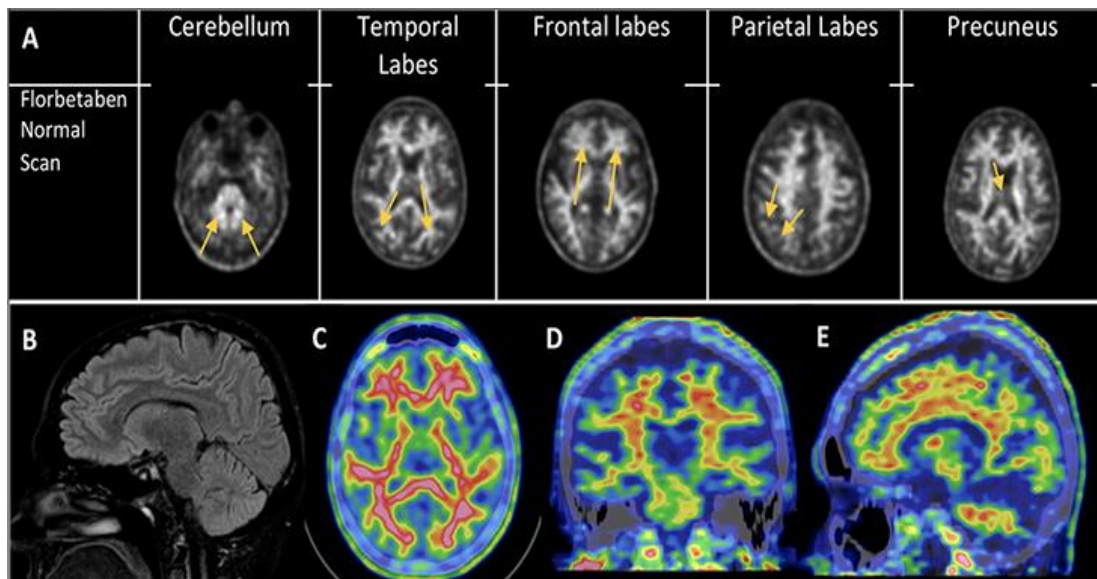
Woman, 52 years old, with neurodegenerative diseases familiarity . From few months appearance of memory deficit and cognitive impairment. MMSE resulted negative (25/30). (A) 18Florbetaben PET axial slices of cerebellum (reference region) and the 4 target regions: no signs of accumulation in none of the 4 target regions, with well-evidenced contrast between gray and white matter (RCTU=1 in all regions). BAPL=1. (B) Sagittal T1-weighted MRI image: non-dilated ventricular system, no atrophy, no areas of altered brain parenchyma signal. (C-E) 18Florbetaben fused PET/CT axial, coronal and sagittal slices.
